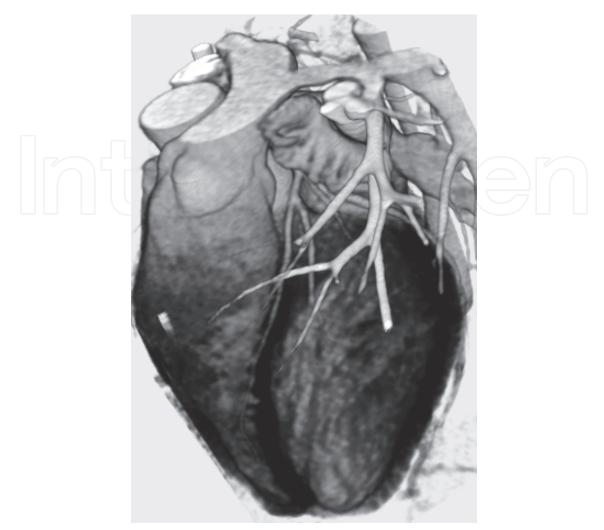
Image of a volume rendering of a heart. The raw data come from a coronary angiogram recorded on a 64-detector CT scanner.
